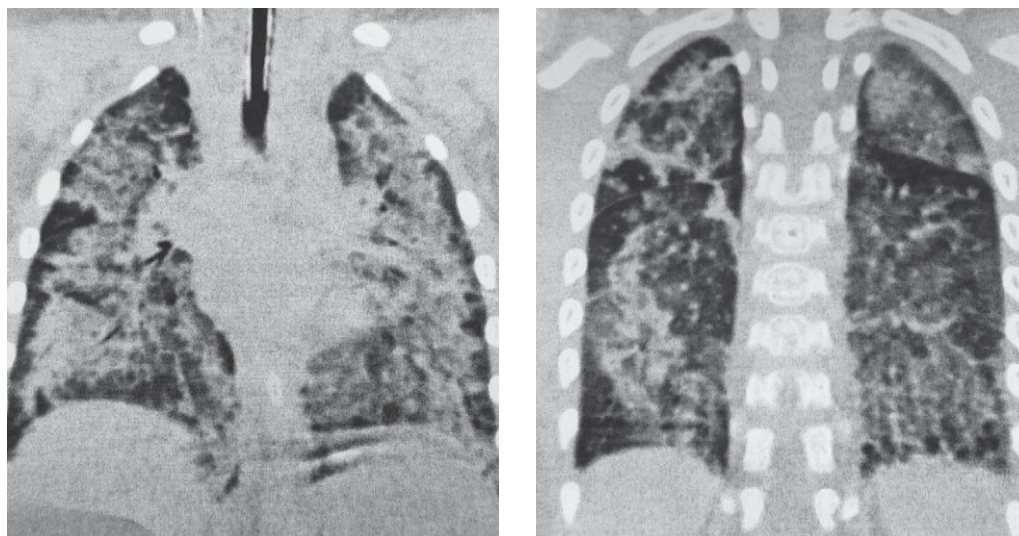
Chest high-resolution computed tomography demonstrating bilateral areas of patchy abnormalities and mixed ground-glass appearance and consolidation.
